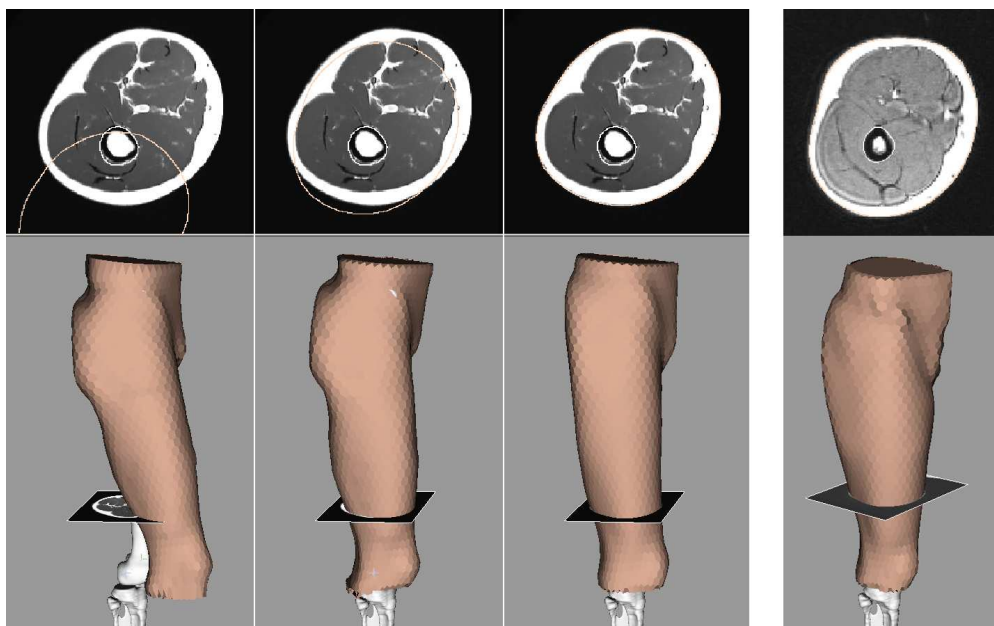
Result of skin automatic segmentation. Left: generic skin model; skin after initialisation from bone poses (skinning); Individual skin after deformable matching. Right: segmented skin from low resolution MRI
